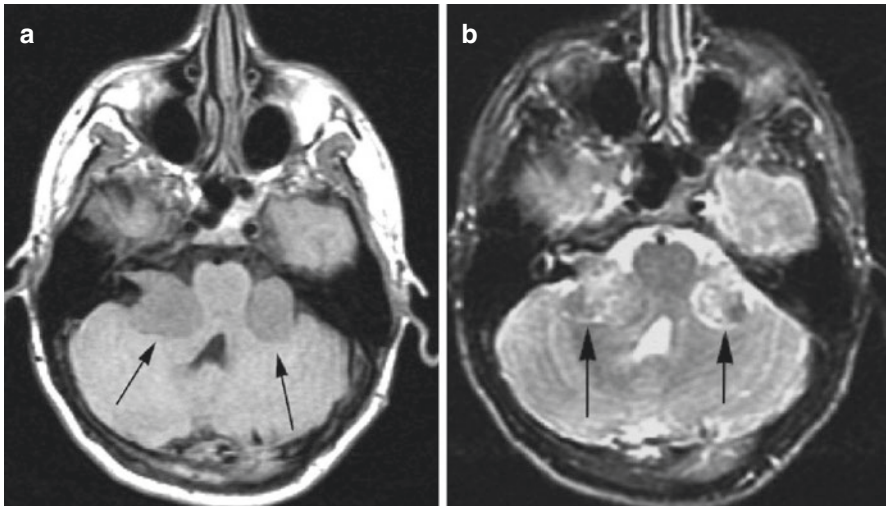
A 19-year-old man with NF2 and bilateral neuromas; (a) axial T1-weighted image shows intermediate signal intensity masses in both cerebellopontine angles (arrow); (b) on axial T2-weighted MRI, the lesion is mild hypointense (arrows)
